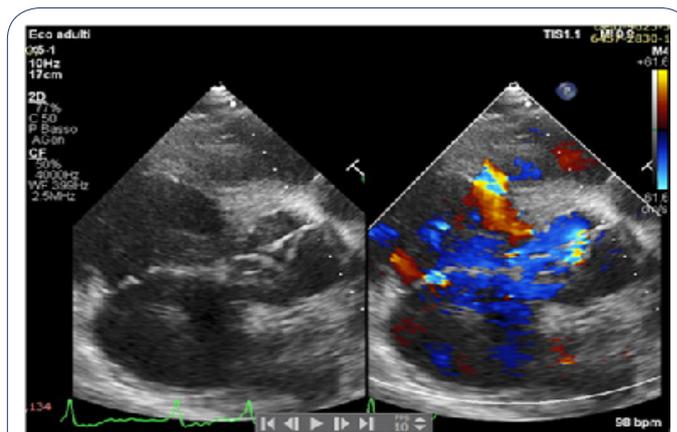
Parasternal short axis.
